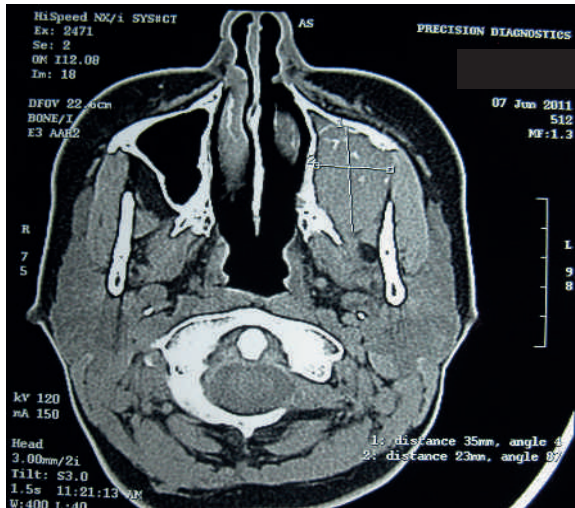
CT scan showing obliteration of left maxillary sinus with destruction of posterior wall of the sinus (Before steroid injection)
